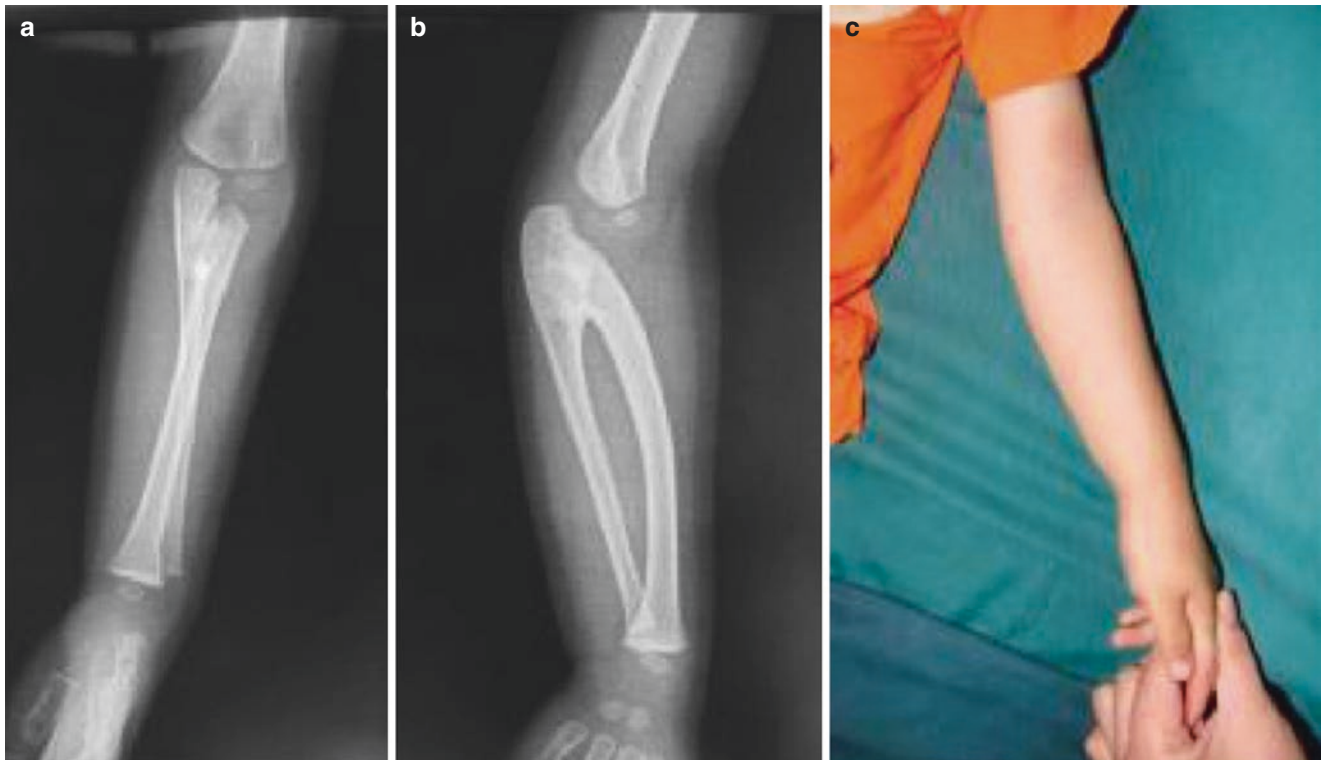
Congenital proximal radioulnar joint fusion (Cleary III type). (a, b) X-ray findings. (c) Deformed appearance
